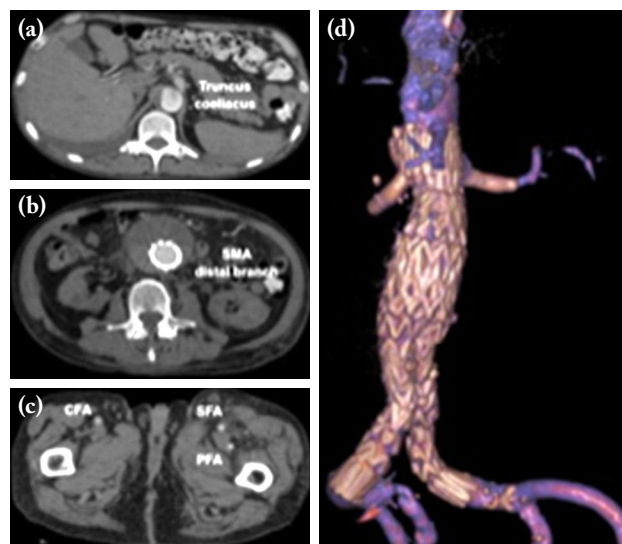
An example for IQS 3. TA-CTA images which was performed on a 65-year-old man with an abdominal aortic aneurysm and chronic kidney disease after EVAR. On axial images, distal branches of visceral arteries and femoral arteries can be seen, as well as aorta, but only proximal segments of visceral arteries and iliac arteries are seen, as well as aorta, on the axial and volume rendered images. (a) Truncus coeliacus and its branches can be seen. (b) Superior mesenteric artery and its distal branches can be seen. (c) Common femoral arteries and its branches can be seen. (d) Only proximal segments of visceral arteries and iliac arteries can be seen on volume rendered images.
